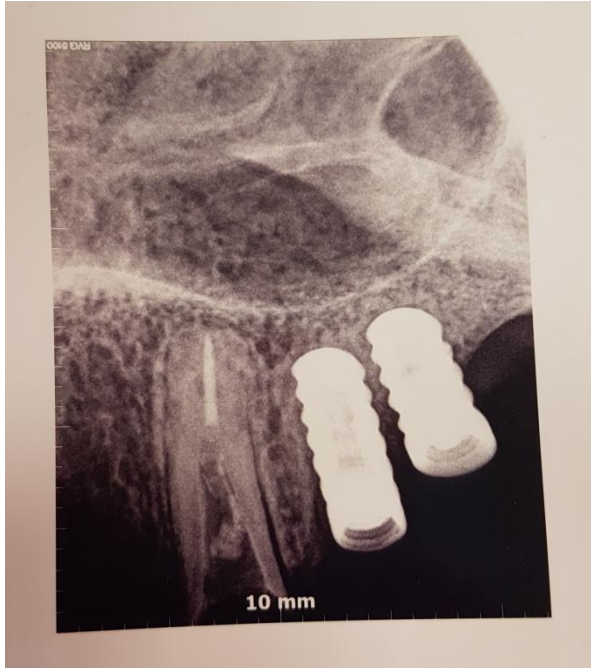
Tooth #23 and two implants radiographic view.
